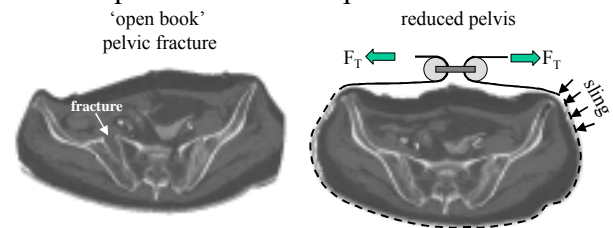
CT scan, sling-induced reduction.
